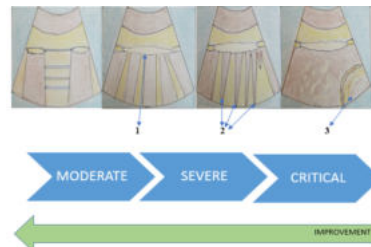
Ultrasound features of Covid-19 pneumonia-1. Irregular thickening of the pleural line, 2. B-lines in focal, multifocal, and confluent patterns, 3. Consolidations in multifocal small, non-translobar, and translobar patterns
